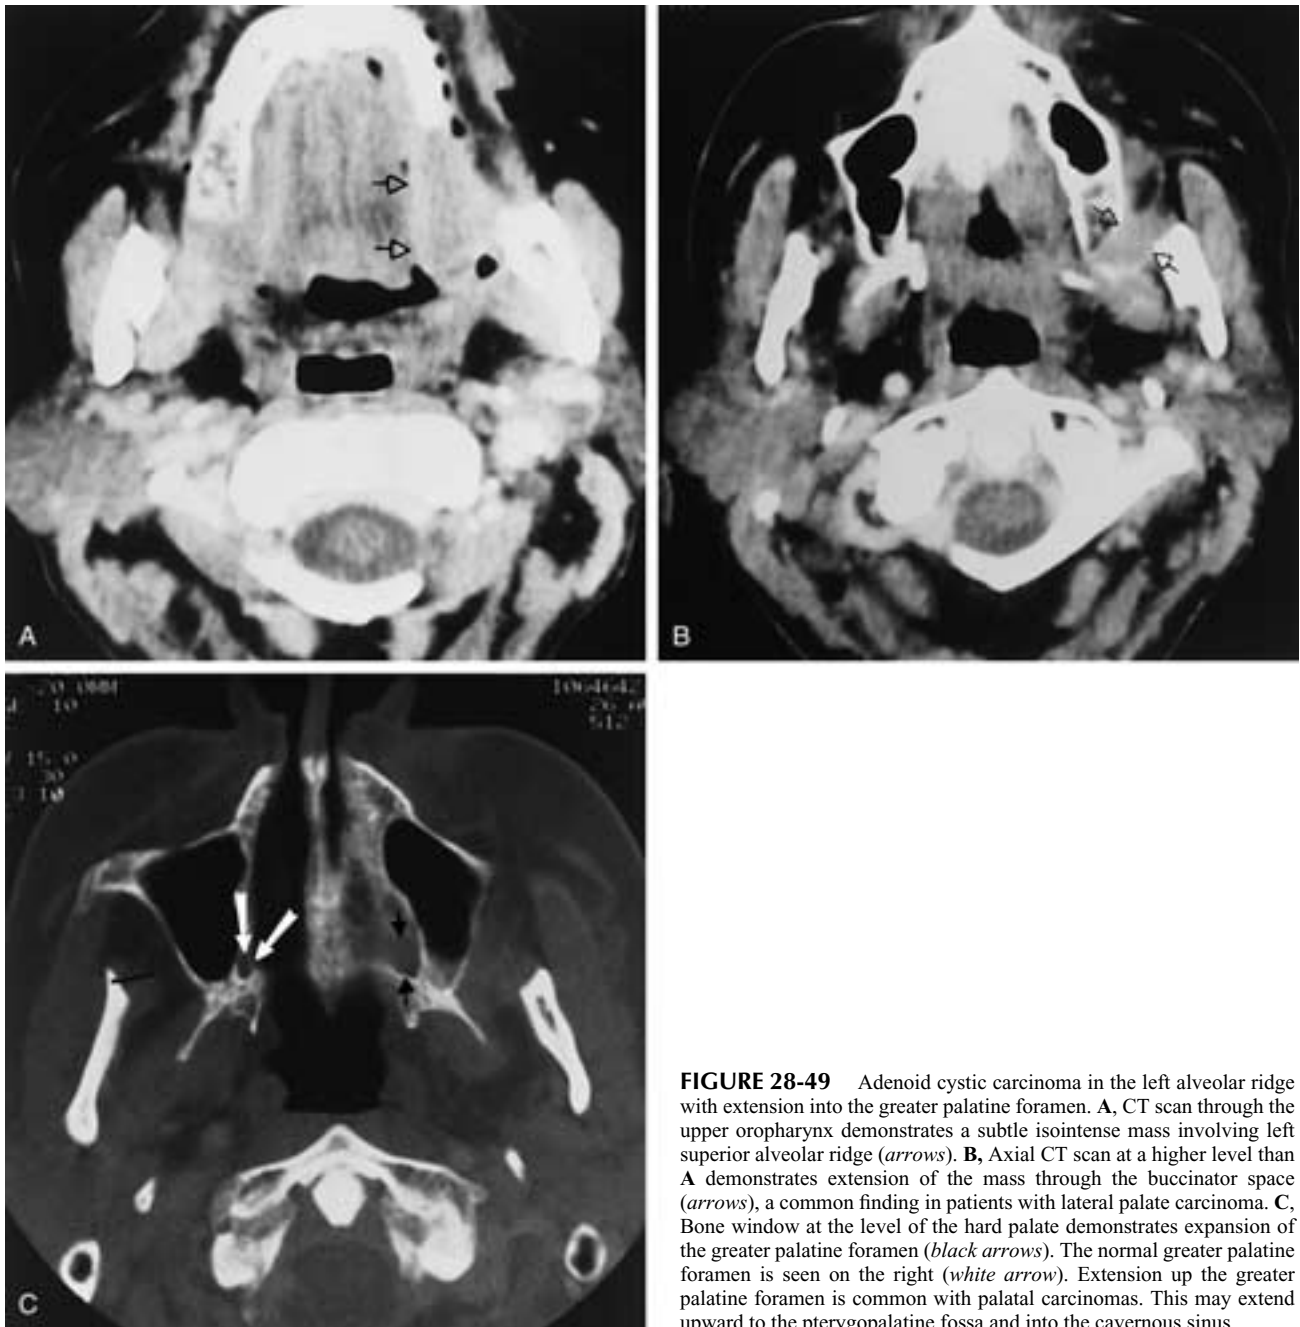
Adenoid cystic carcinoma in the left alveolar ridge with extension into the greater palatine foramen. A, CT scan through the upper oropharynx demonstrates a subtle isointense mass involving left superior alveolar ridge (arrows). B, Axial CT scan at a higher level than A demonstrates extension of the mass through the buccinator space (arrows), a common finding in patients with lateral palate carcinoma. C, Bone window at the level of the hard palate demonstrates expansion of the greater palatine foramen (black arrows). The normal greater palatine foramen is seen on the right (white arrow). Extension up the greater palatine foramen is common with palatal carcinomas. This may extend upward to the pterygopalatine fossa and into the cavernous sinus.
